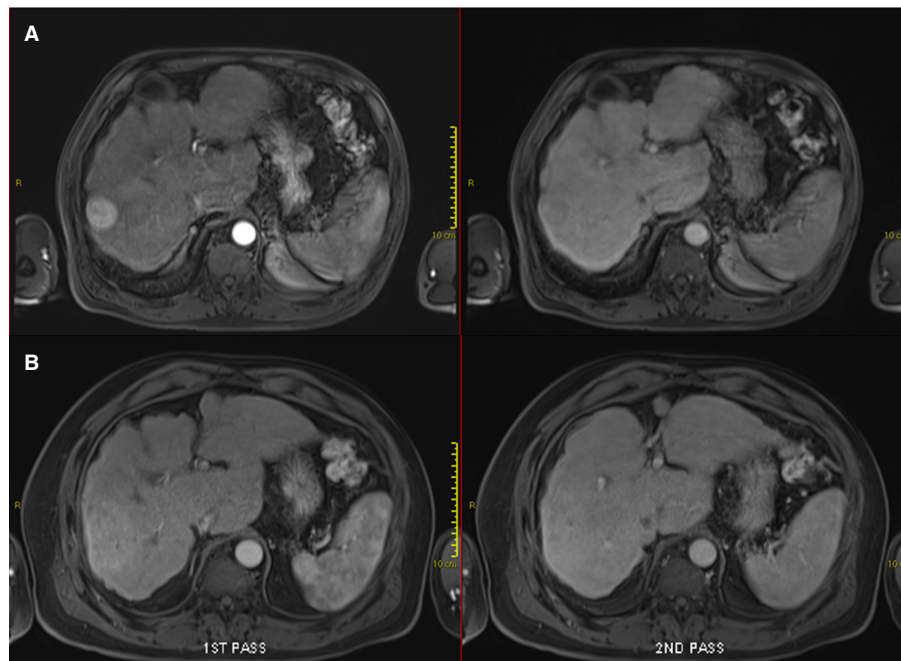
Contrast-enhanced magnetic resonance imaging demonstrating early imaging changes before and after stereotactic body radiotherapy (SBRT): pre-SBRT showing typical arterially enhancing lesion with subsequent wash-out (A); and 3 months after SBRT showing the surrounding arterial enhancement without subsequent wash-out observed, indicative of reactive hyperaemia (B)
